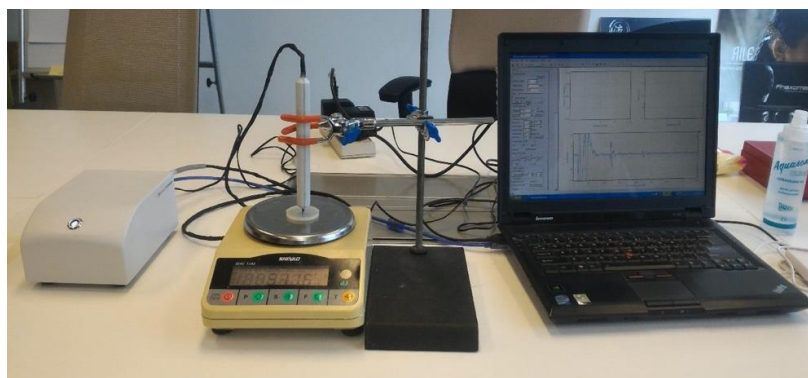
Setup for calibration of Ultrasound Indentation device
